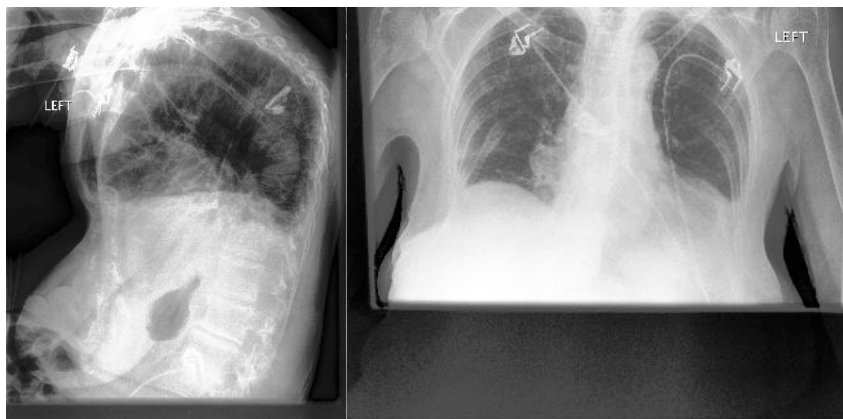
Example of chest X-ray images from the CheXpert dataset. (A) – Lateral view. (B) – Frontal View (Irvin et al., 2019).
